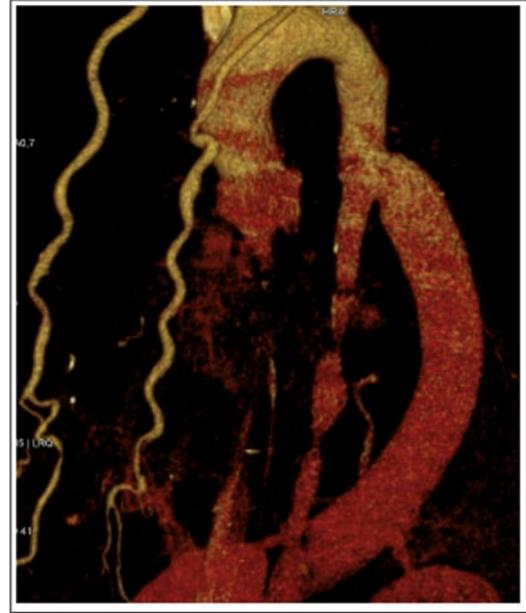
Control CT at one month showing a patent bypass.
